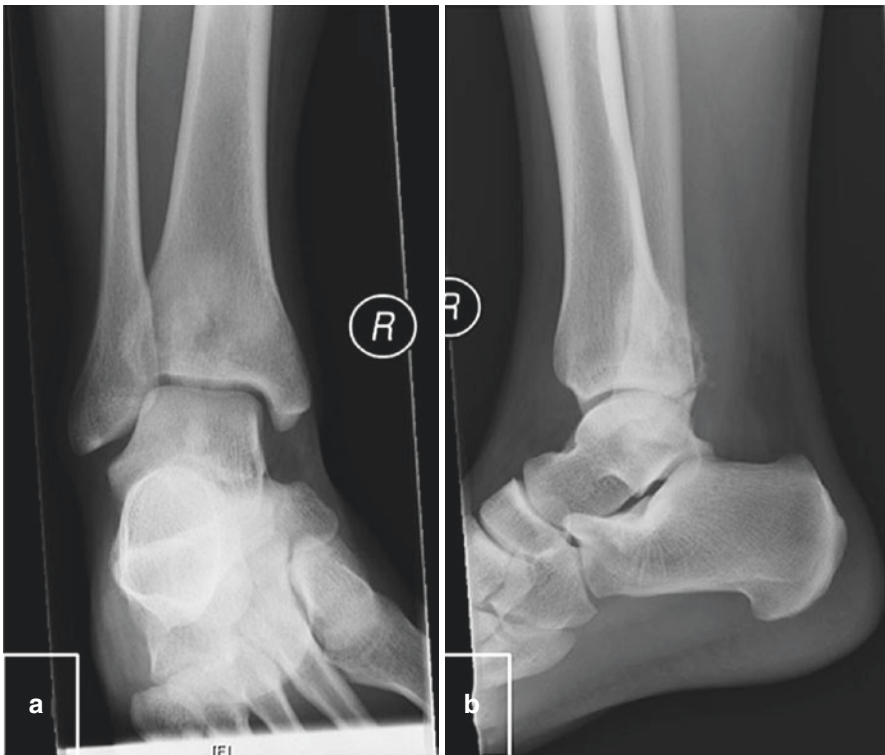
AP (a) and lateral (b) radiographs of the ankle demonstrating a mixed sclerotic/lytic lesion in the distal tibia with periosteal reaction and extraosseous extension. Biopsy confirmed an osteosarcoma
